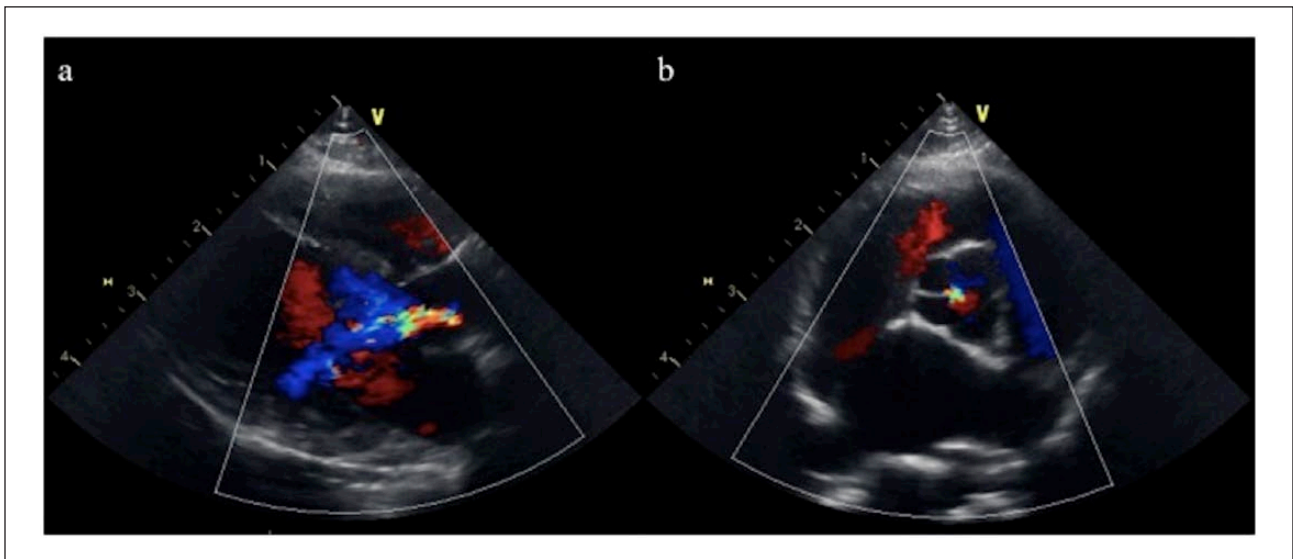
Colour Doppler echocardiographic images from the right parasternal (a) long-axis and (b) short-axis views at the aortic valve level, demonstrating moderate central aortic regurgitation (long-axis view)
